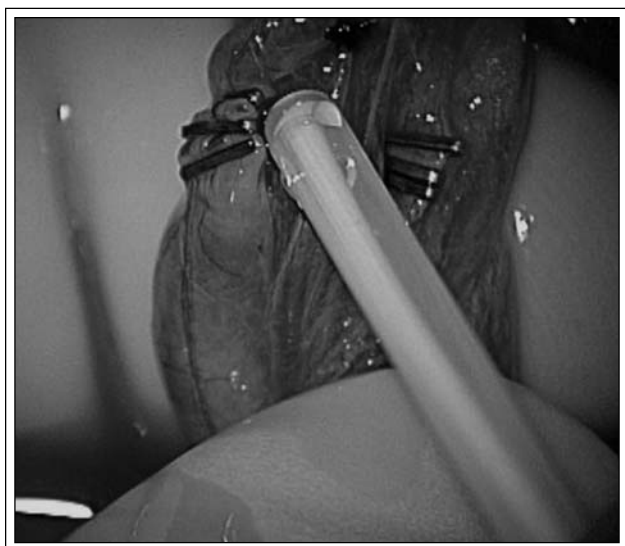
The micro Doppler probe is used to confirm arterial flow.
